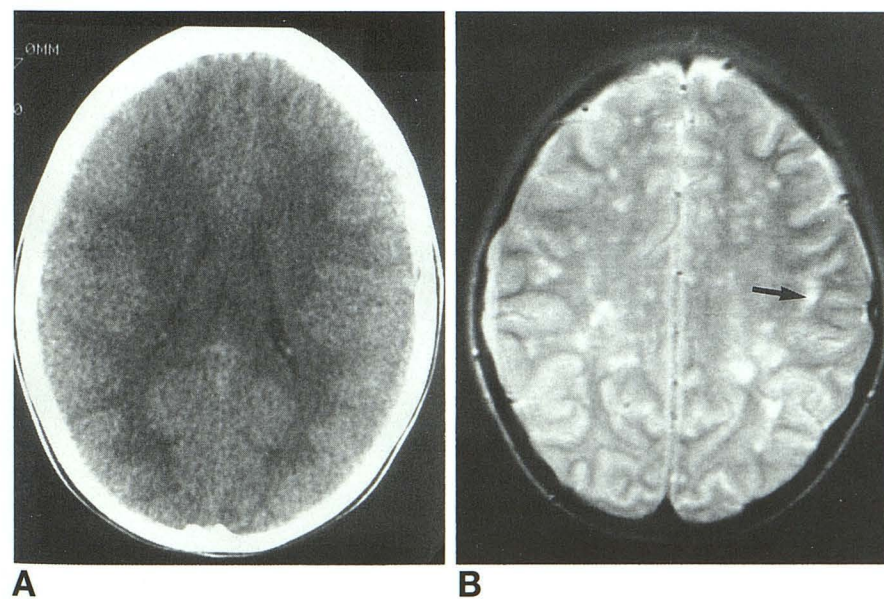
Case 2. A, Axial CT scan. B, Axial T2-weighted MR image (2100/80/2). Preferential involvement of the deep arcuate fibers is indicated by the arrow.
